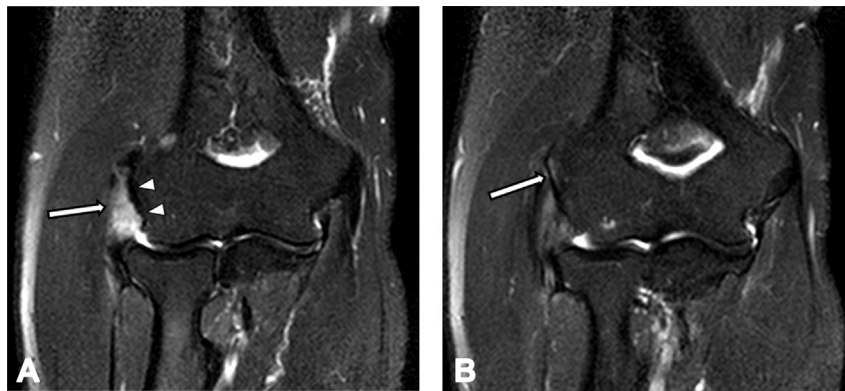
A 58-year-old male with right elbow pain for 4 years. A. Coronal fat-suppressed FSE T2-weighted image showing complete tear of the proximal portion of the common extensor tendon and lateral collateral ligament (arrow), suggesting severe injury. Cortical irregularity along the lateral epicondyle (arrowheads) is shown. B. Coronal fat-suppressed FSE T2-weighted image (posterior to A) showing subcortical bone marrow edema as high signal intensity in the lateral epicondyle (arrow).
